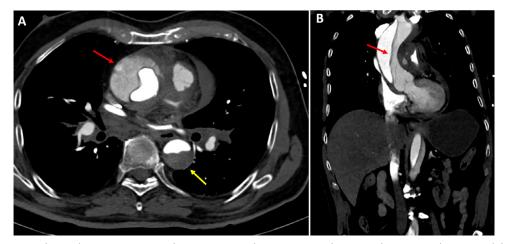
(A) Computed tomography axial view in a patient with a type A aortic dissection. Ascending aorta dissection (red arrow) and descending aorta dissection (yellow arrow); (B) sagittal view of type A dissection extending into the right subclavian artery. (Color version of figure is available online.)
